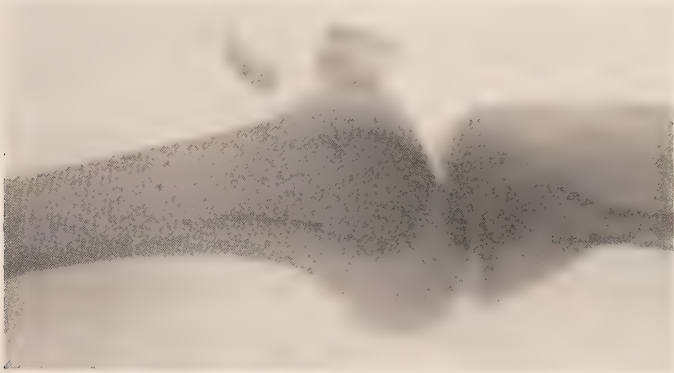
Transverse fracture of patella with separation of fragments. (Roentgenogram of Dr. G. C. Bird.)
